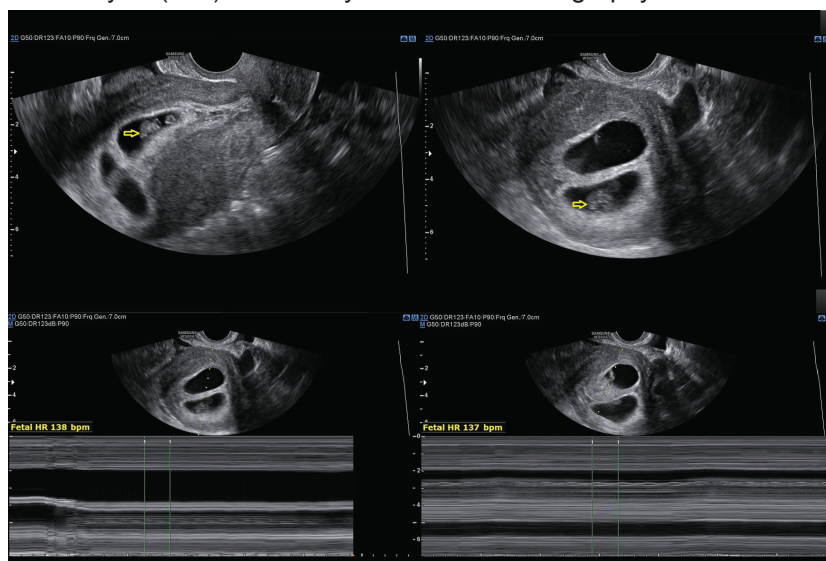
Transvaginal ultrasound showed live twin intrauterine pregnancies in separate gestational sacs. Yellow arrows show the two intrauterine fetal poles with cardiac activity.
